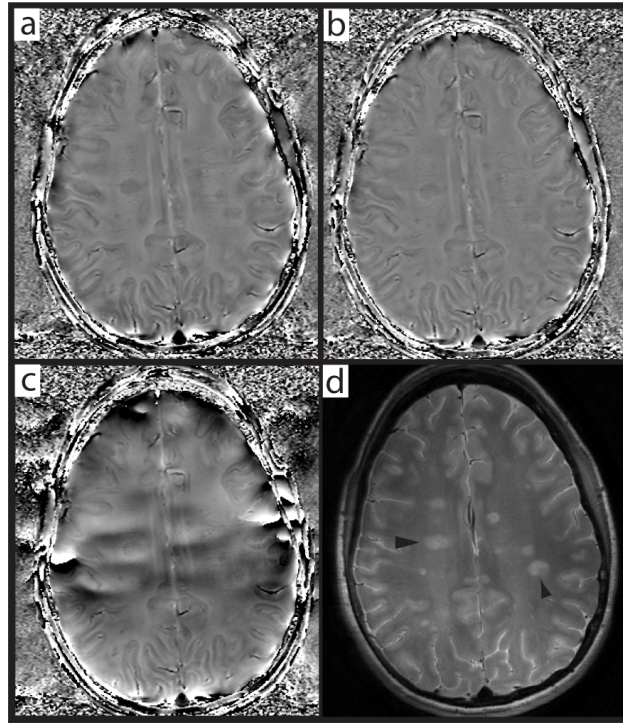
Axial images from a 29-year-old RRMS patient acquired at 4.7 T with (a) the new method using  $64f \times 32e$  square fitting and extraction window with 0.0625 filter strength, (b) standard method using 0.125 filter strength, (c) standard method using 0.0625 filter strength, and (d) T2-weighted FSE image identifying inflammatory lesion in MS. Arrowheads in (d) show example lesions used for phase contrast measures.
